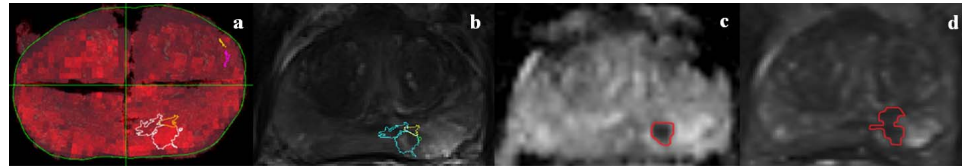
(a) Multi grade tumor region displayed on nuclear density map on pseudo whole mount pathology section; (b) Registered tumor region displayed on corresponding T_2 -weighted MRI; ROI drawn at hypointense region at registered tumor location on (c) ADC Map and (d) T_2 Map.
